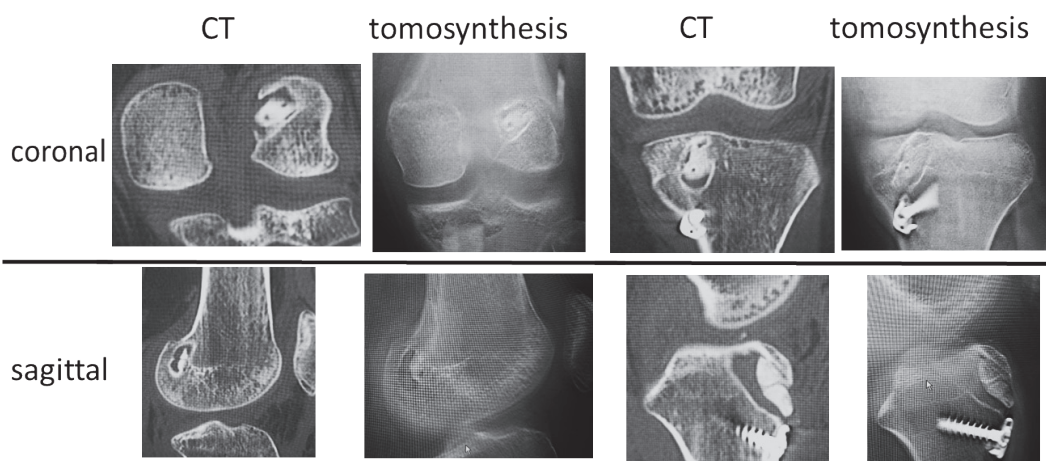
Comparison of CT and TS (in Coronal Plane and Sagittal Plane for Femur and Tibia)
